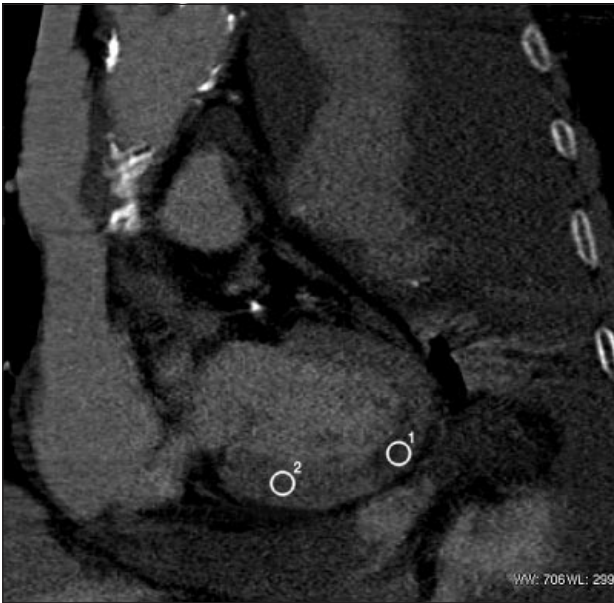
Computed tomography — coronal reconstructed image. Area 1 shows hypoenhancement in the left ventricular free wall (HU ~63.1), representing the area of myocardial infarction. Area 2 shows normal myocardial enhancement (HU ~100.8). Also note the contrast extravasation in the pericardial cavity, haemopericardium, and haemothorax.
